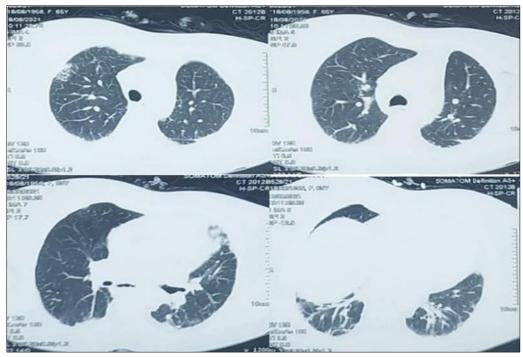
Chest CT scan showing pulmonary fibrosis
